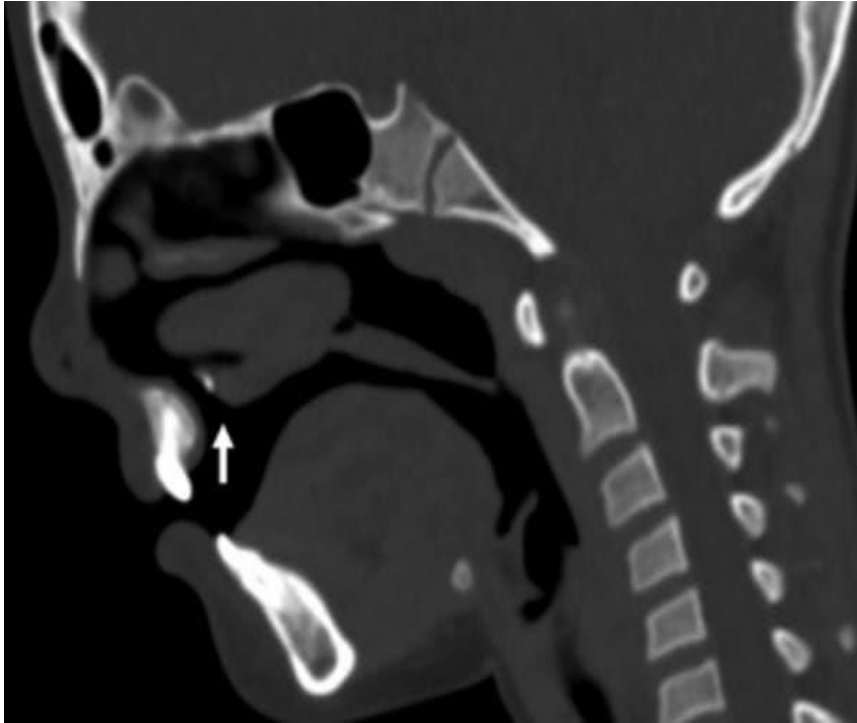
Sagittal oblique CT images. (Zachary2015).
